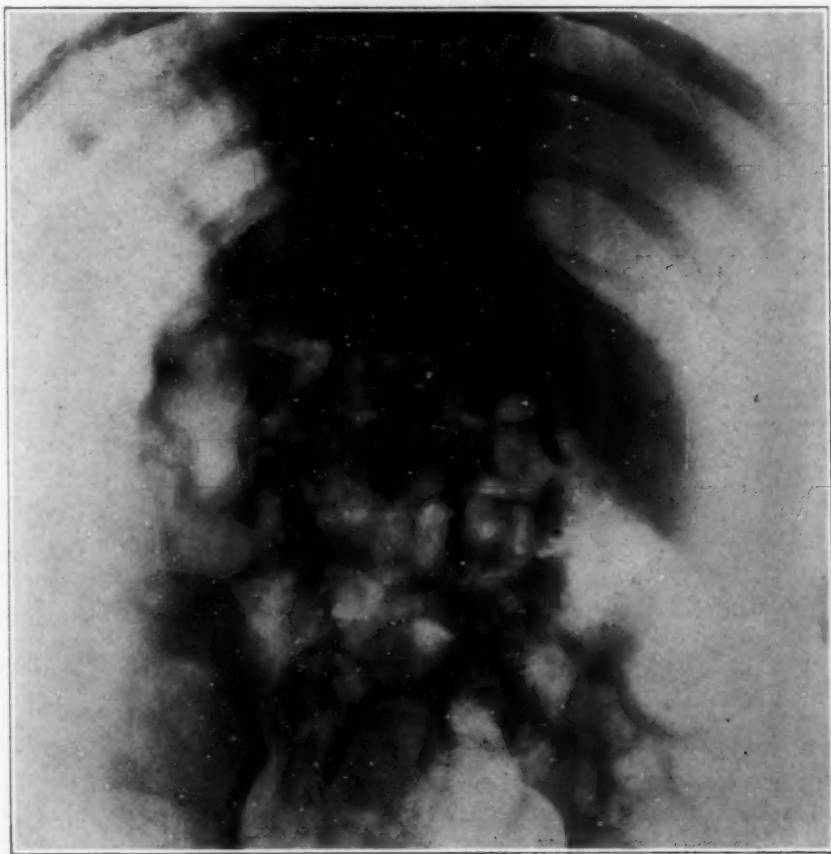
Roentgenogram of same spine as in Figure 6 taken eighteen months later. Note growth of the defect, also fusion of the ninth and tenth ribs.
